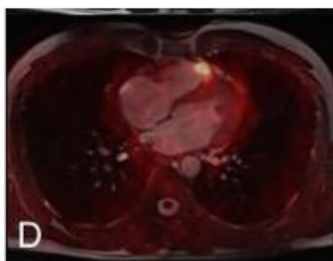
Fused axial ^{18}F -FDOPA PET/ T2 MRI image of the chest
